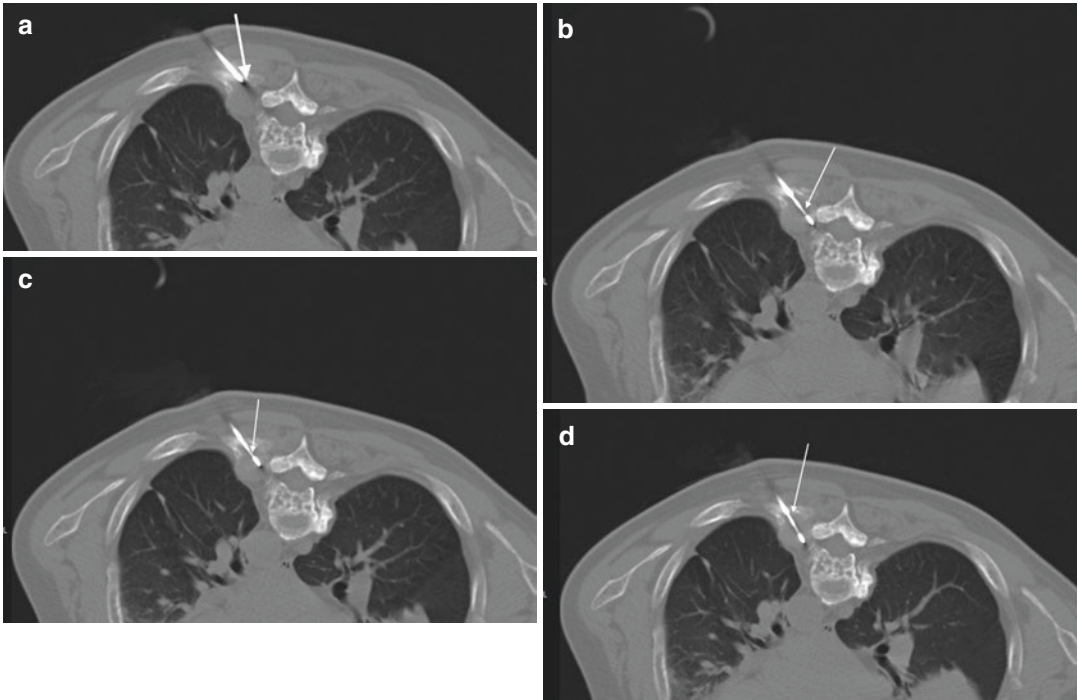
A 66-year-old male with a history of multiple myeloma and new posterior left T6 rib lesion. Axial CT image (a) shows placement of a guide needle (*arrow*) at the margin of a large lytic soft tissue mass within the head of the rib. A medial trajectory is used for this posterior approach. Axial CT image (b) shows chamber of cutting
